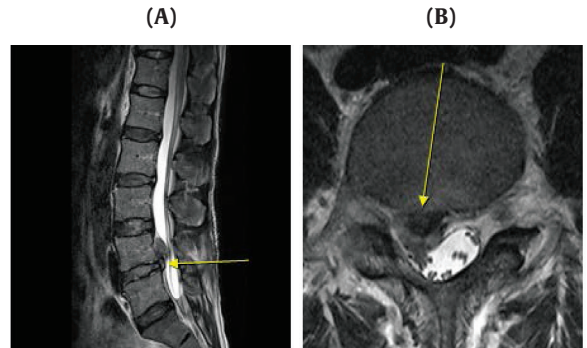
Lumbar spine MRI (T2-weighted image) of Case 2 on Oct 13, 2017. (A) Sagittal (B) Axial L4-5. MRI, magnetic resonance imaging.
